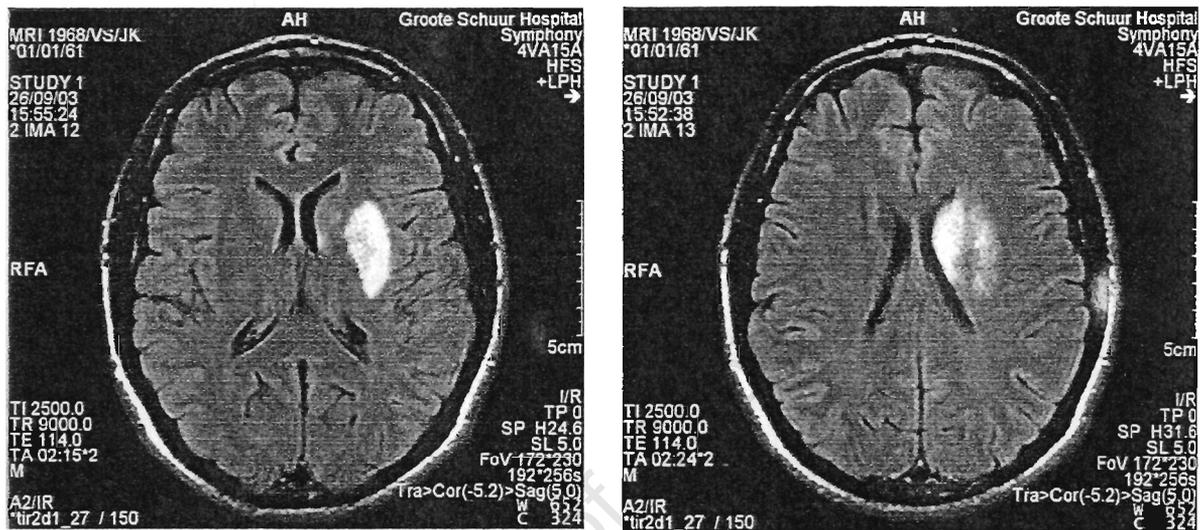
MRI scans of patient JH
